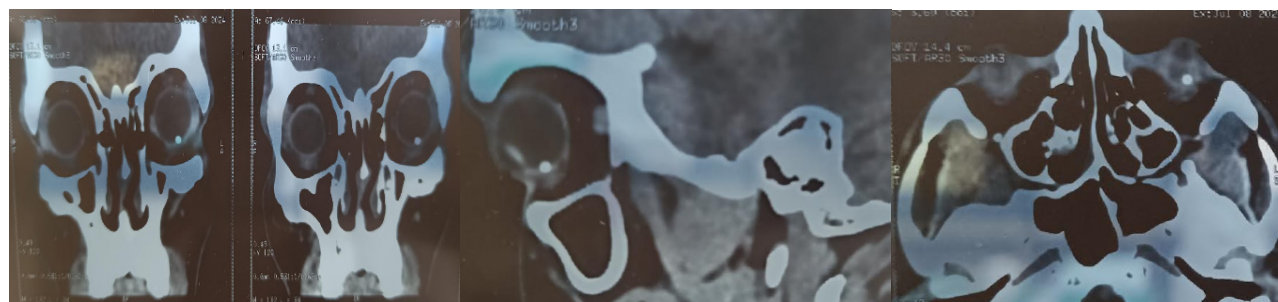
CT Scan Showing Intraocular Foreign Body
